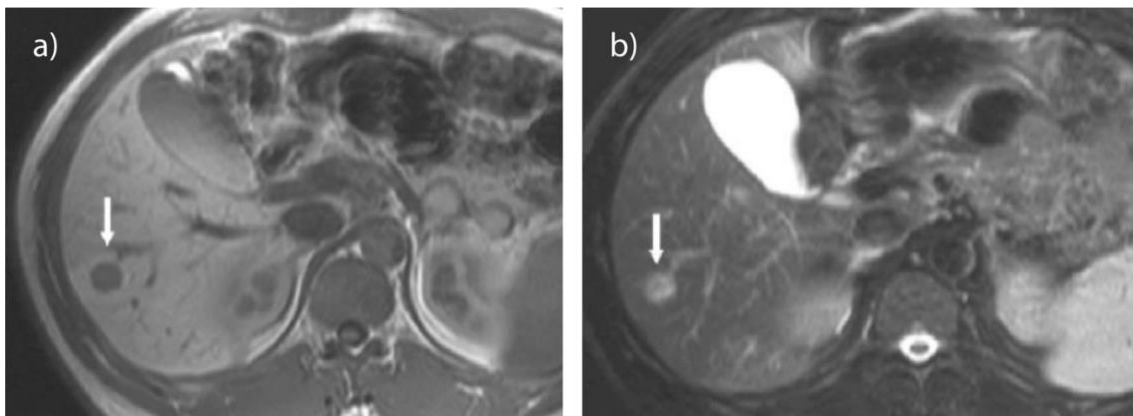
Axial MRI of a hepatic NET metastasis. a) T1-weighted, b) T2-weighted image of the metastatic mass (white arrow).^[3]
